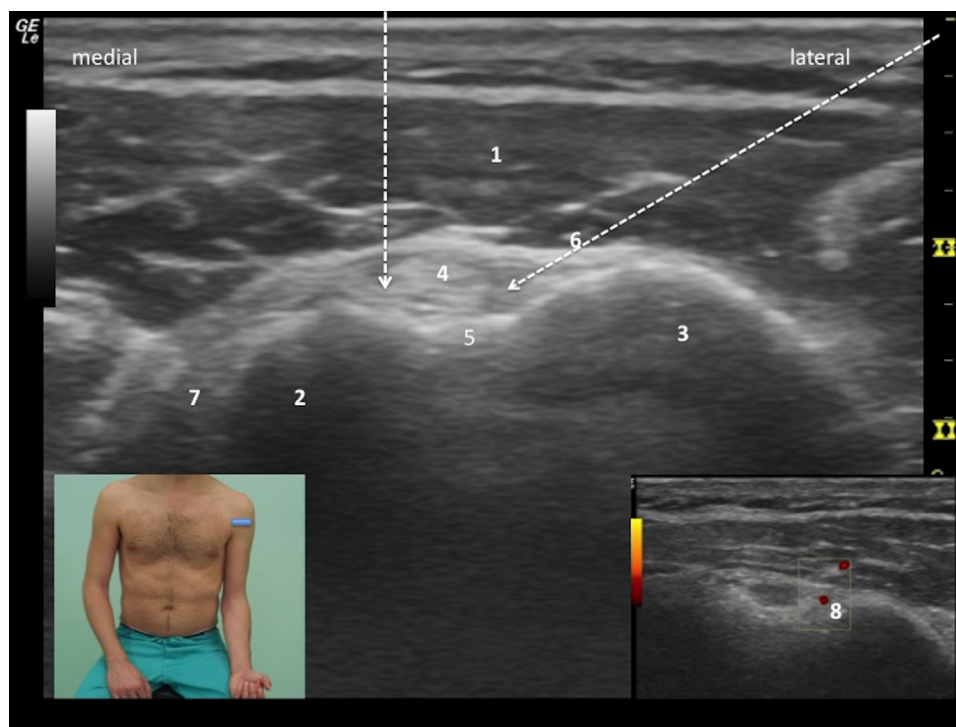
Biceps tendon. The inset shows the position of the patient and the linear ultrasound probe: probe transverse across superior aspect of bicipital groove. Arm adducted, hand supinated. Note that the biceps tendon appears hyperechoic. Landmark: 1—deltoid muscle; 2—lesser tuberosity; 3—greater tuberosity; 4—biceps tendon; 5—floor of groove; 6—transverse ligament; 7—subscapularis tendon; 8—anterior circumflex artery. (Color version of figure is available online.)
